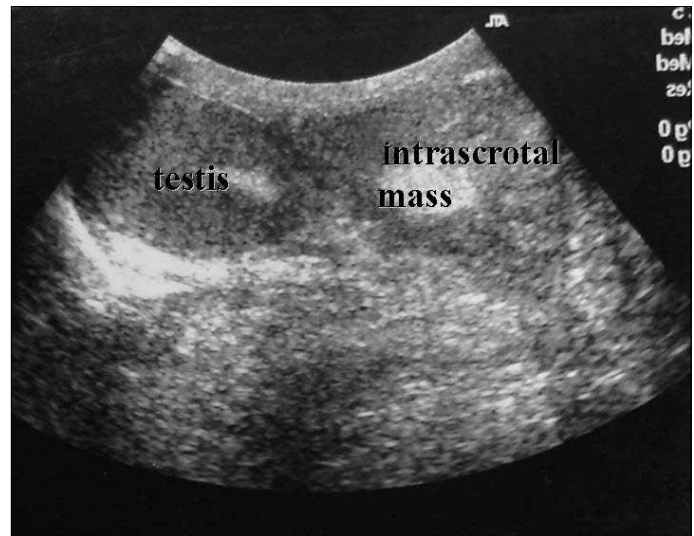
Ultrasonographic appearance of intrascrotal mass
